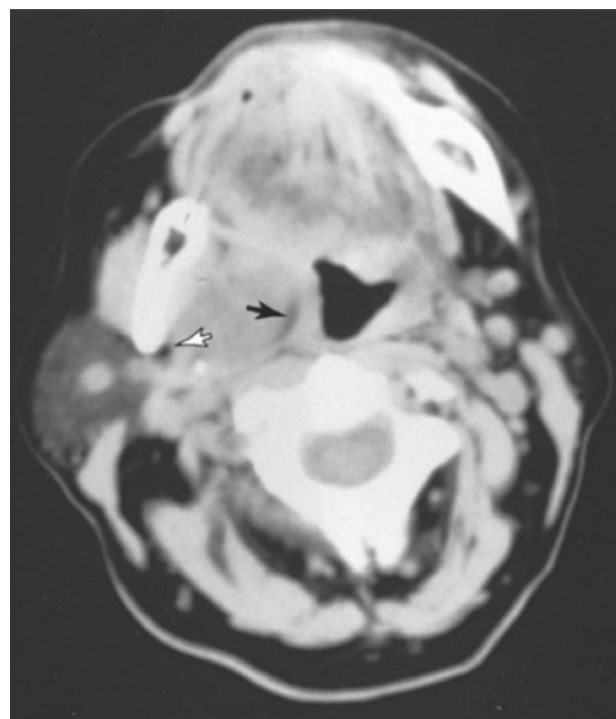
Computed tomography scan demonstrating a pleomorphic adenoma arising de novo in the prestyloid parapharyngeal space. The tumor displaces fat medially (closed arrow). A fat plane separates the tumor from the parotid gland (open arrow).
